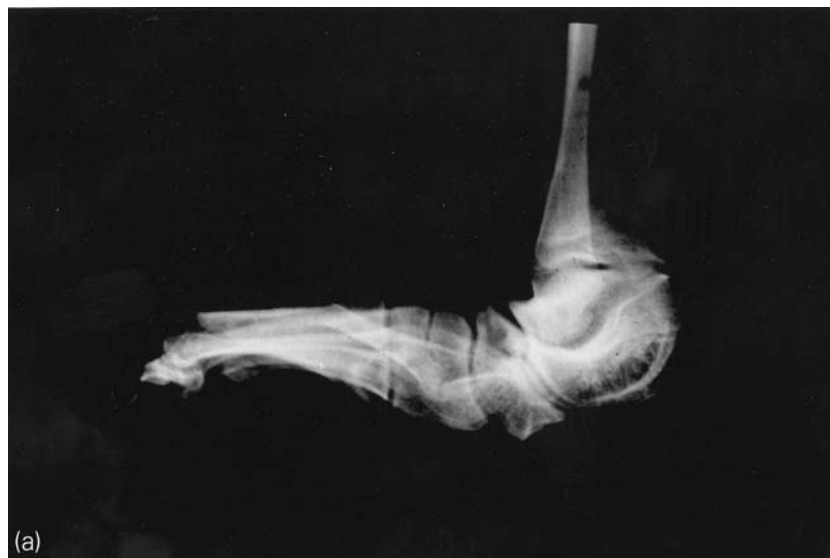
(a) Preoperative radiograph showing severe rockerbottom deformity. Calcaneal equinus and the midfoot break can be seen. (b) Radiograph of the apparatus used for correction. An axial hinge is located over the navicular/midfoot to correct the midfoot break, opposing olive wires are placed in the calcaneus, and lateral olive wires are placed in the metatarsals. The calcaneus is moved out of equinus and valgus and the metatarsals are moved out of dorsiflexion and valgus by lengthening the posterior, anterior, and lateral rods and shortening the medial rod. (c) Radiograph during correction. As the calcaneus is distracted, the midfoot is pushed distally. (d) The natural arch of the foot is recreated by shortening the medial threaded rods and lengthening the lateral telescopic rod. Note again the olives on the lateral metatarsal and the lateral calcaneus. After correction, the entire midfoot is fused to maintain the plantigrade position.
